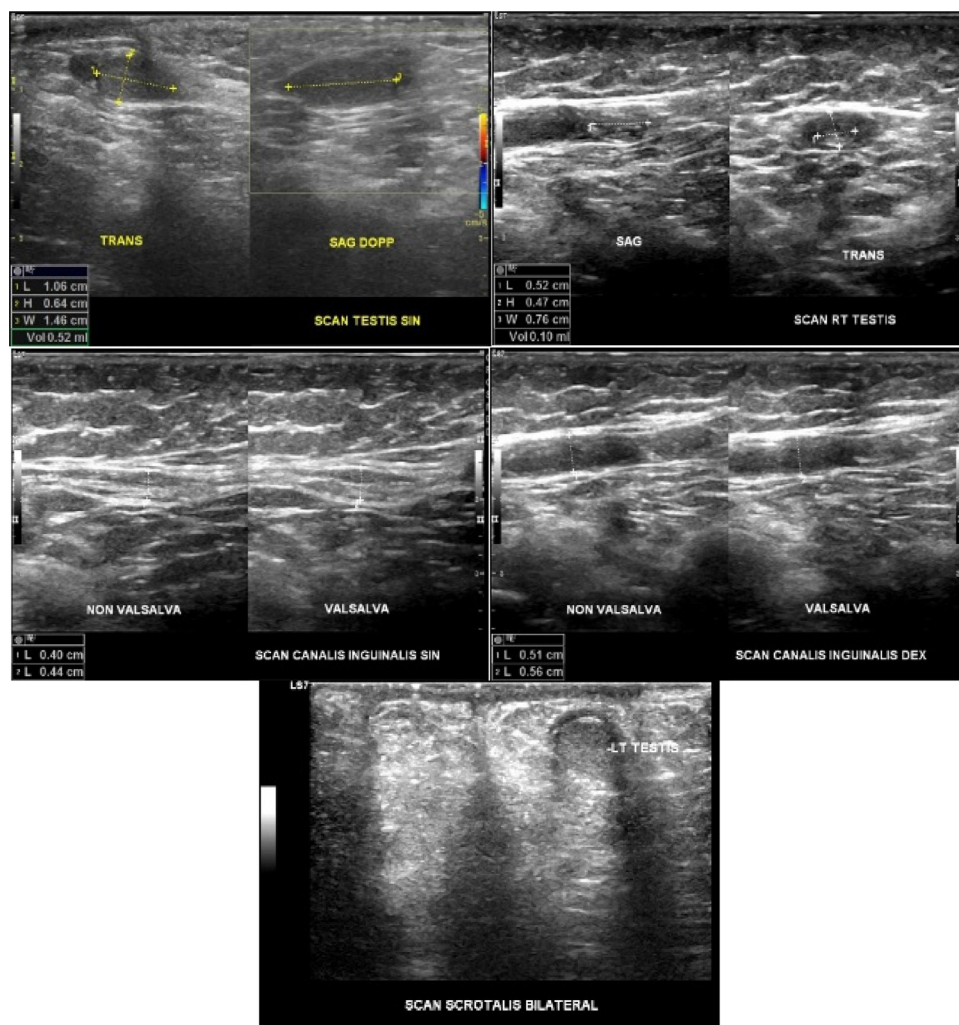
Scrotal ultrasonography undescended the right testicle (UDT) and the volume of the right and left testes was 0.1 cc and 0.52 cc, respectively.
